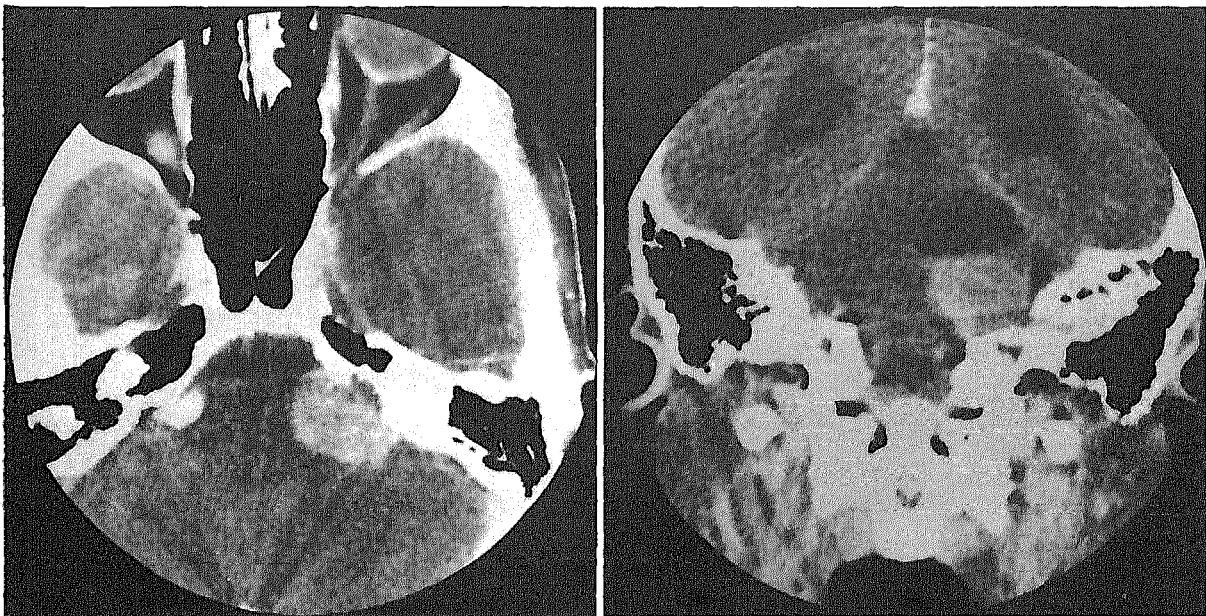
(left). Left acoustic neuroma, axial CT section. The large enhanced tumor mass erodes the posterior aspect of the petrous pyramid.
